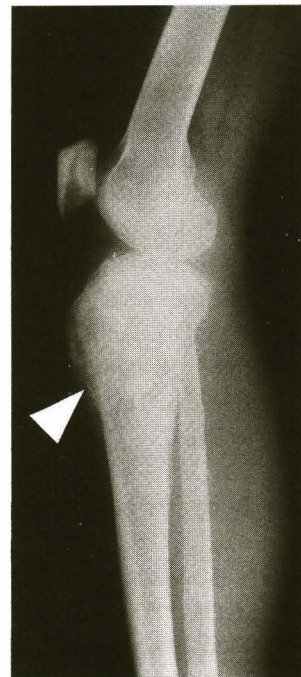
The plain film right leg, lateral view, shows a bone mass (arrowhead) involving the epiphysial and metaphysial part of the proximal tibia. It destroys the bone in a moth-eaten pattern and breaks through the bony cortex. Focal spotty calcifications are noted.
